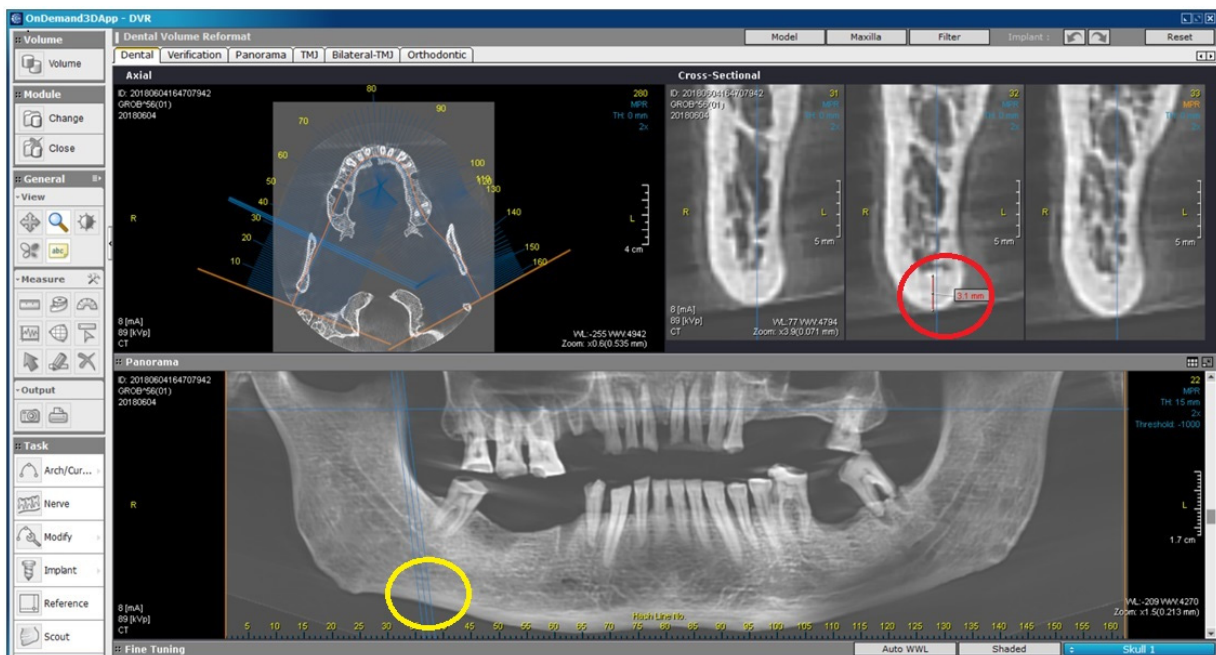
Measurement of the antegonion index (AI) on the CBCT scan. The AI was measured on a line parallel to the anterior edge of the mandibular ramus (circled in yellow) in the sagittal projection (circled in red).
